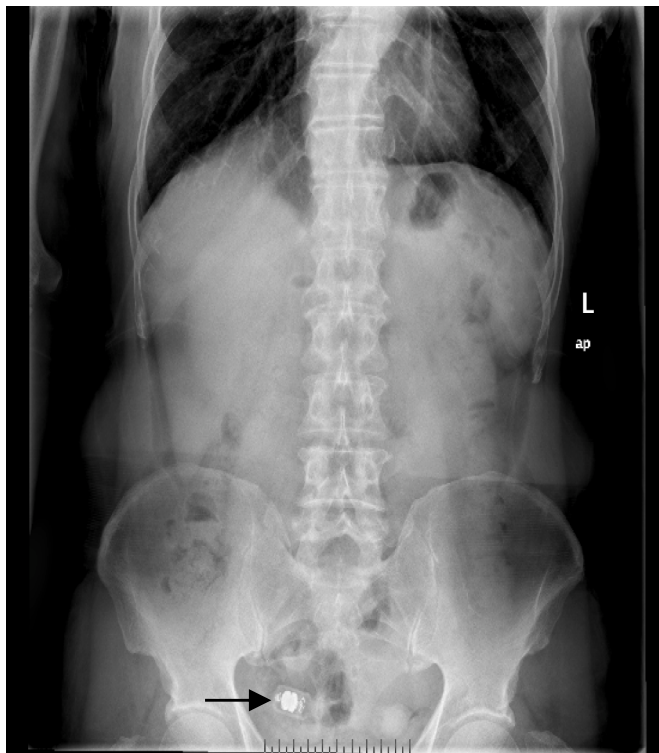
X-ray film of abdomen showed a suspected capsule endoscopy on the right side of pelvic cavity (arrow).
